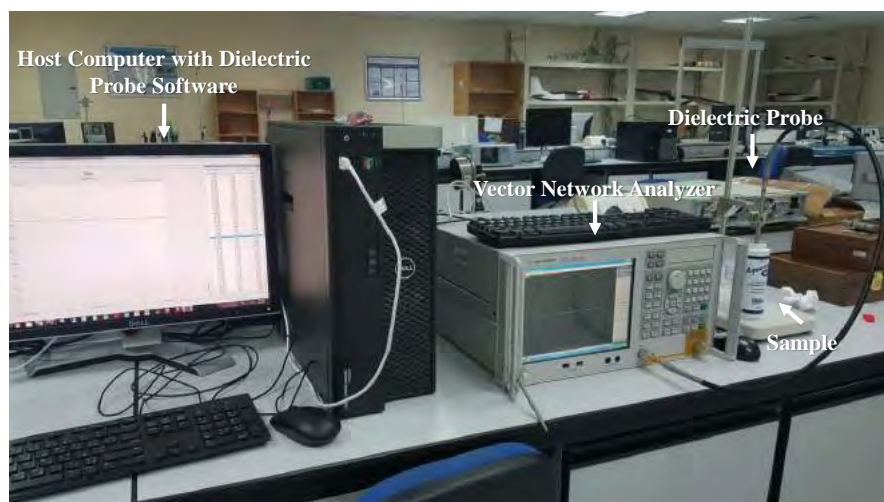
The setting used to measure AquaSonic 100 ultrasound gel dielectric properties.
